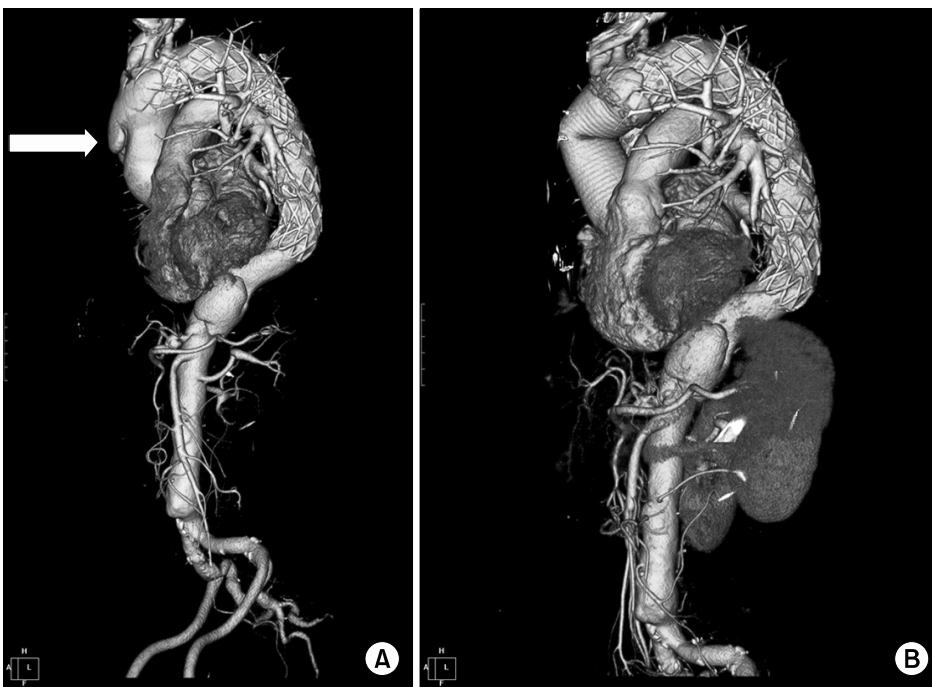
(A) Computed tomography image showing retrograde type A aortic dissection (arrow) at three months after endovascular repair and (B) last follow-up image at twenty months after the ascending aorta replacement.
